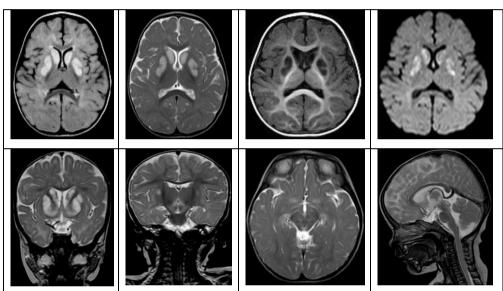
MRI Brain showing bilateral hyper intense lesions of basal ganglia, thalamus
